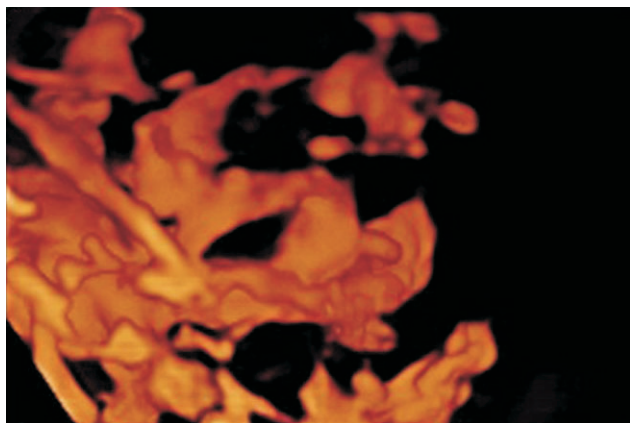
Color power Doppler image of placenta accreta
